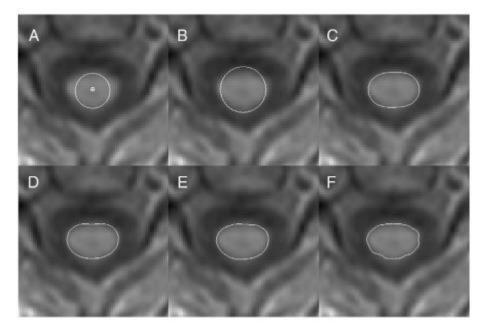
Evolution of the cervical cord active surface from A to F (copied from "Rapid semiautomatic segmentation of the spinal cord from magnetic resonance images: application in multiple sclerosis" by MA Horsfield et al, 2010, Neuroimage, 50(2):446-55)
